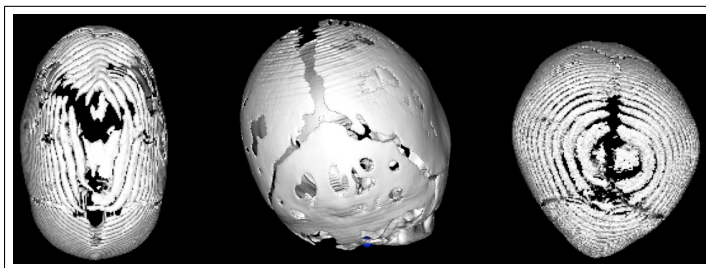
Imperfections like holes, rings and noise as seen on some older CT scans can make processing and shape analysis difficult.
